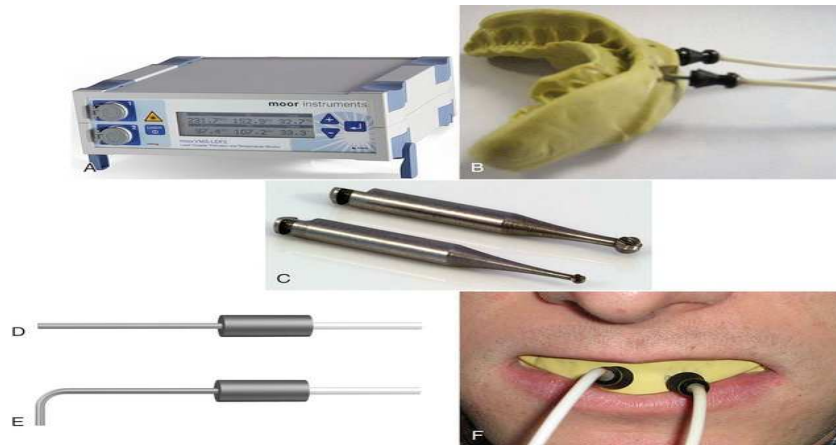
Laser Doppler Flowmetry
